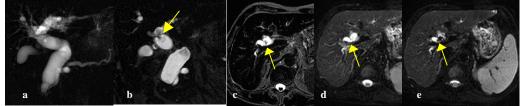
Pseudodefect on MRCP caused by bile flow artifact in a patient with choledochocele and choledochal cyst. a:single-slice MRCP b:source image of multi-slice MRCP c: heavily T2-weighted TSE, d:SE-EPI(b=0) e: black-blood SE-EPI (b=8)
